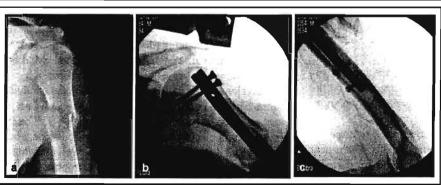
Pathological fracture of the left humerus. A) Pre-operative X-ray showing fracture site. B) Intra-operative X-rays showing proximal fixation. C) Distal fixation of intramedullary nail
